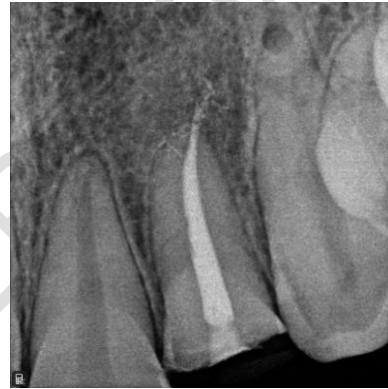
Radiograph - After RCT
